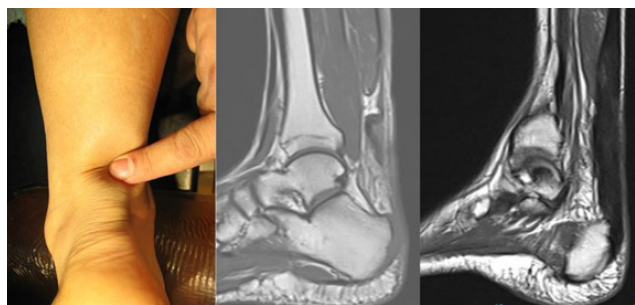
Detection of gap by preoperative palpation. Total tear on preoperative MRI. Healed state of the tendon by MRI control in the 6th month after percutaneous repair.
